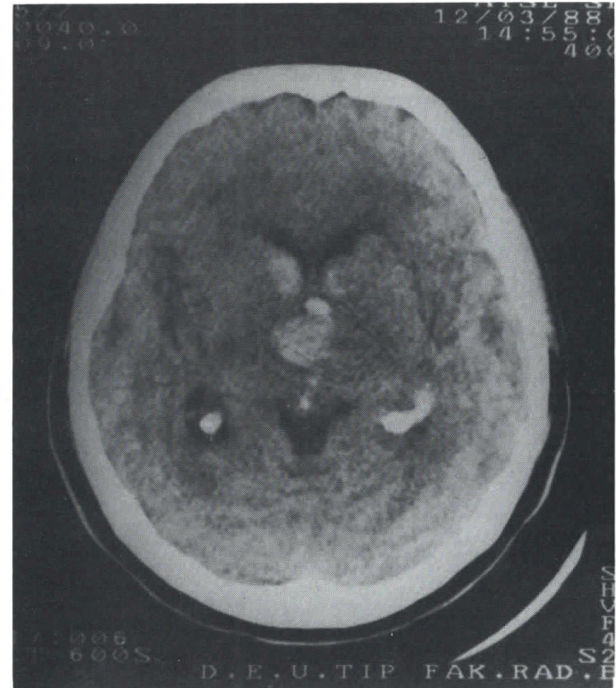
Nonenhanced Computed Tomography showing right thalamic and bilateral caudate nucleus hematoma.
